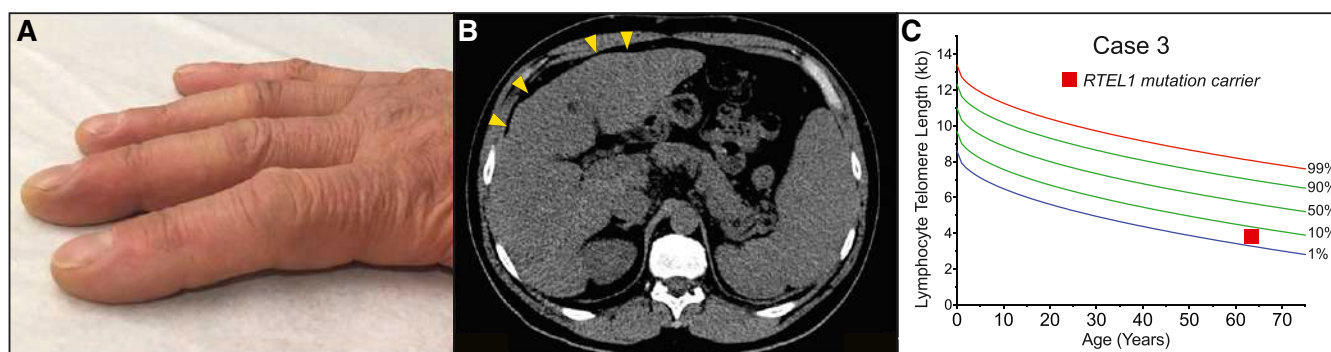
Clubbing and dyspnea can be a presenting feature of telomere-mediated hepatopulmonary syndrome. (A) Image of digital clubbing typically seen. (B) Abdominal CT image showing liver with nodular edges (yellow arrowheads) and secondary splenomegaly due to portal hypertension. (C) The lymphocyte telomere length by flowFISH in older patients with short telomere syndrome presenting over age 60 overlaps with the lower decile of the normal range.
